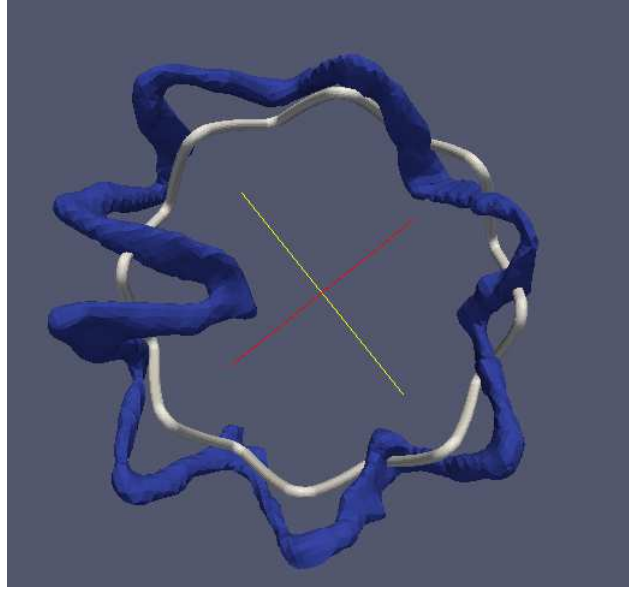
Result of ICP registration between the undeformed model (white) and CT image (blue).
